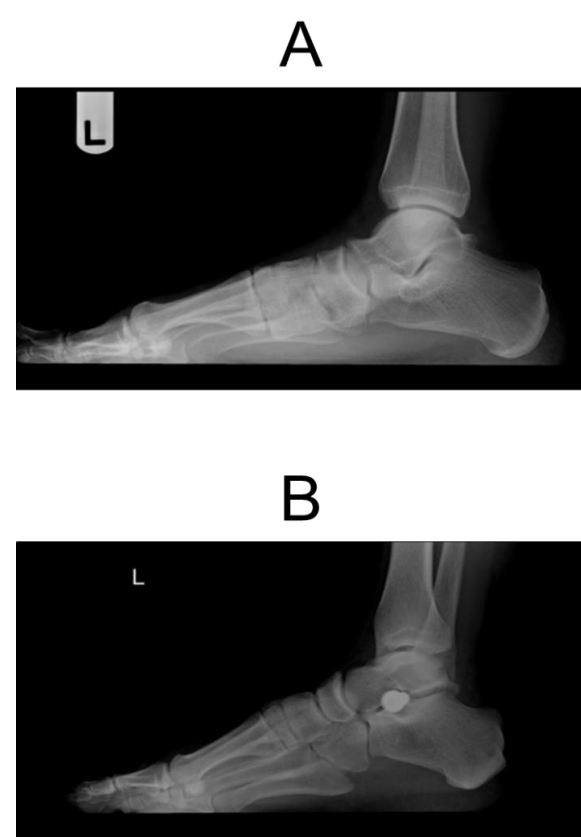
Weight-bearing lateral radiographs of a patient exhibiting talotarsal joint dislocation (TTJD) with a sagittal plane deformity (A) before correction and (B) after insertion of an extraosseous talotarsal stabilization Type II implant. Realignment and stabilization of the sagittal plane deformity is shown.
